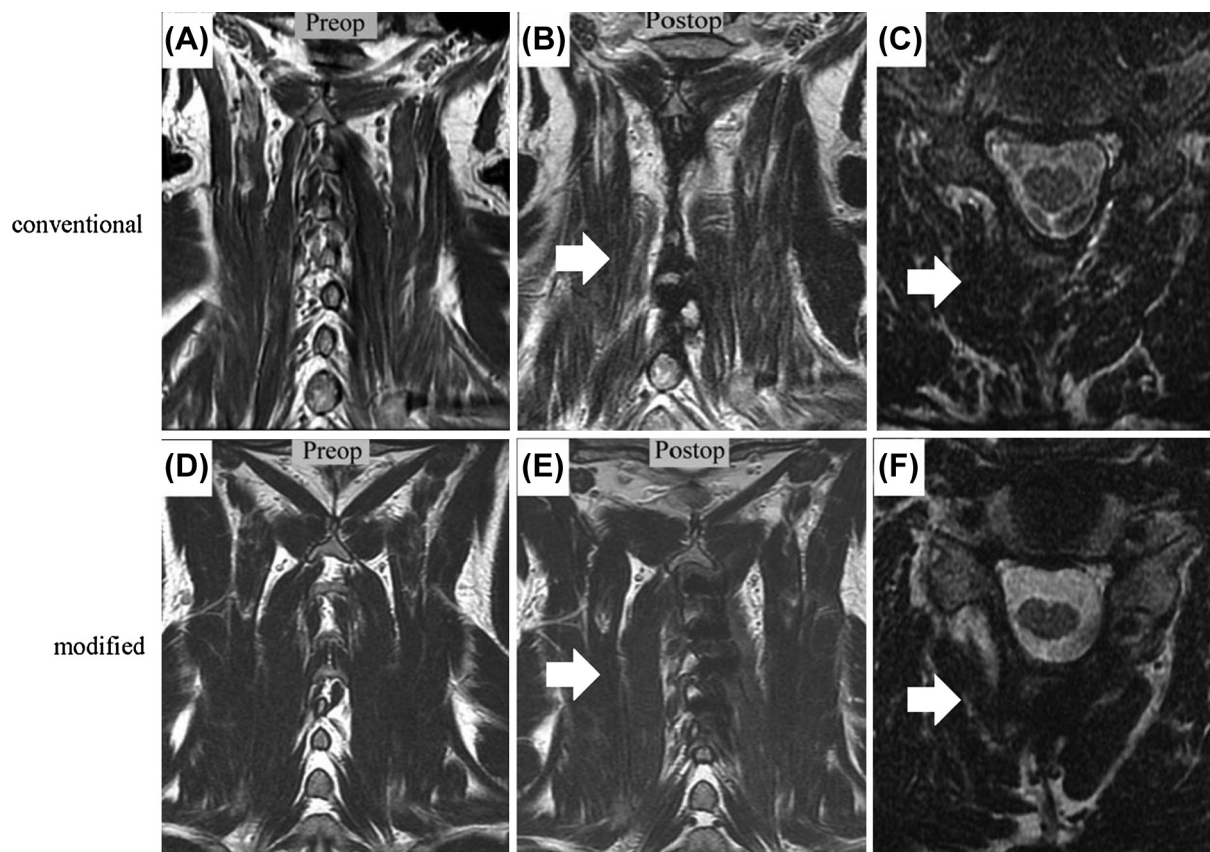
T2-weighted MRI of (A–C) conventional (A, B as coronal view; C as postoperative axial view) and (D–F) modified (D, E as coronal view; F as postoperative axial view) expansive open-door laminoplasty at 12 months pre-/postoperatively. Lesser right-side paraspinal muscle (white arrow) fibrosis is noted in the picture of modified techniques after operation. MRI = magnetic resonance imaging.
